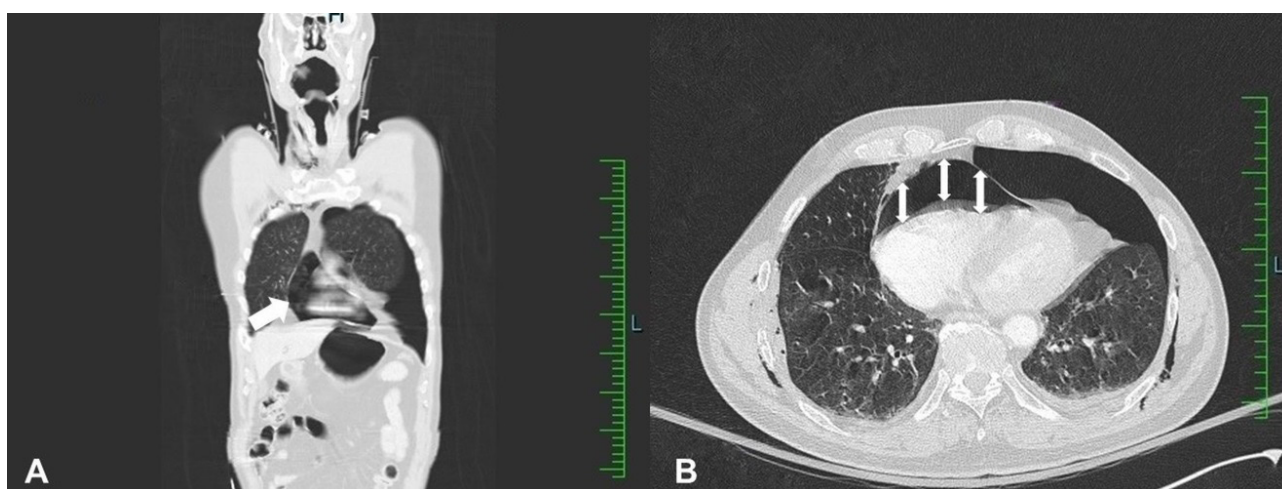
CT scans showing air collection in the pericardial sac.
